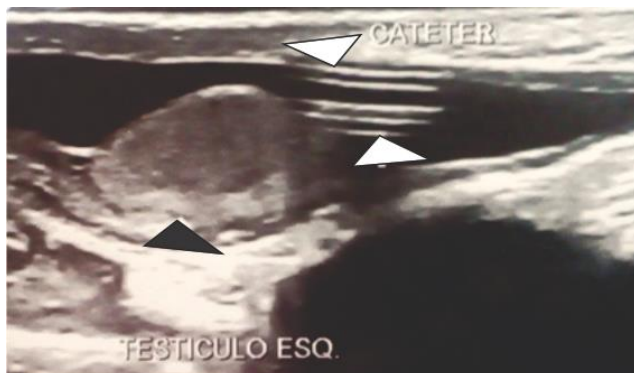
Scrotal ultrasound showing the presence of the catheter (white arrows) near the left testicle (black arrow).
